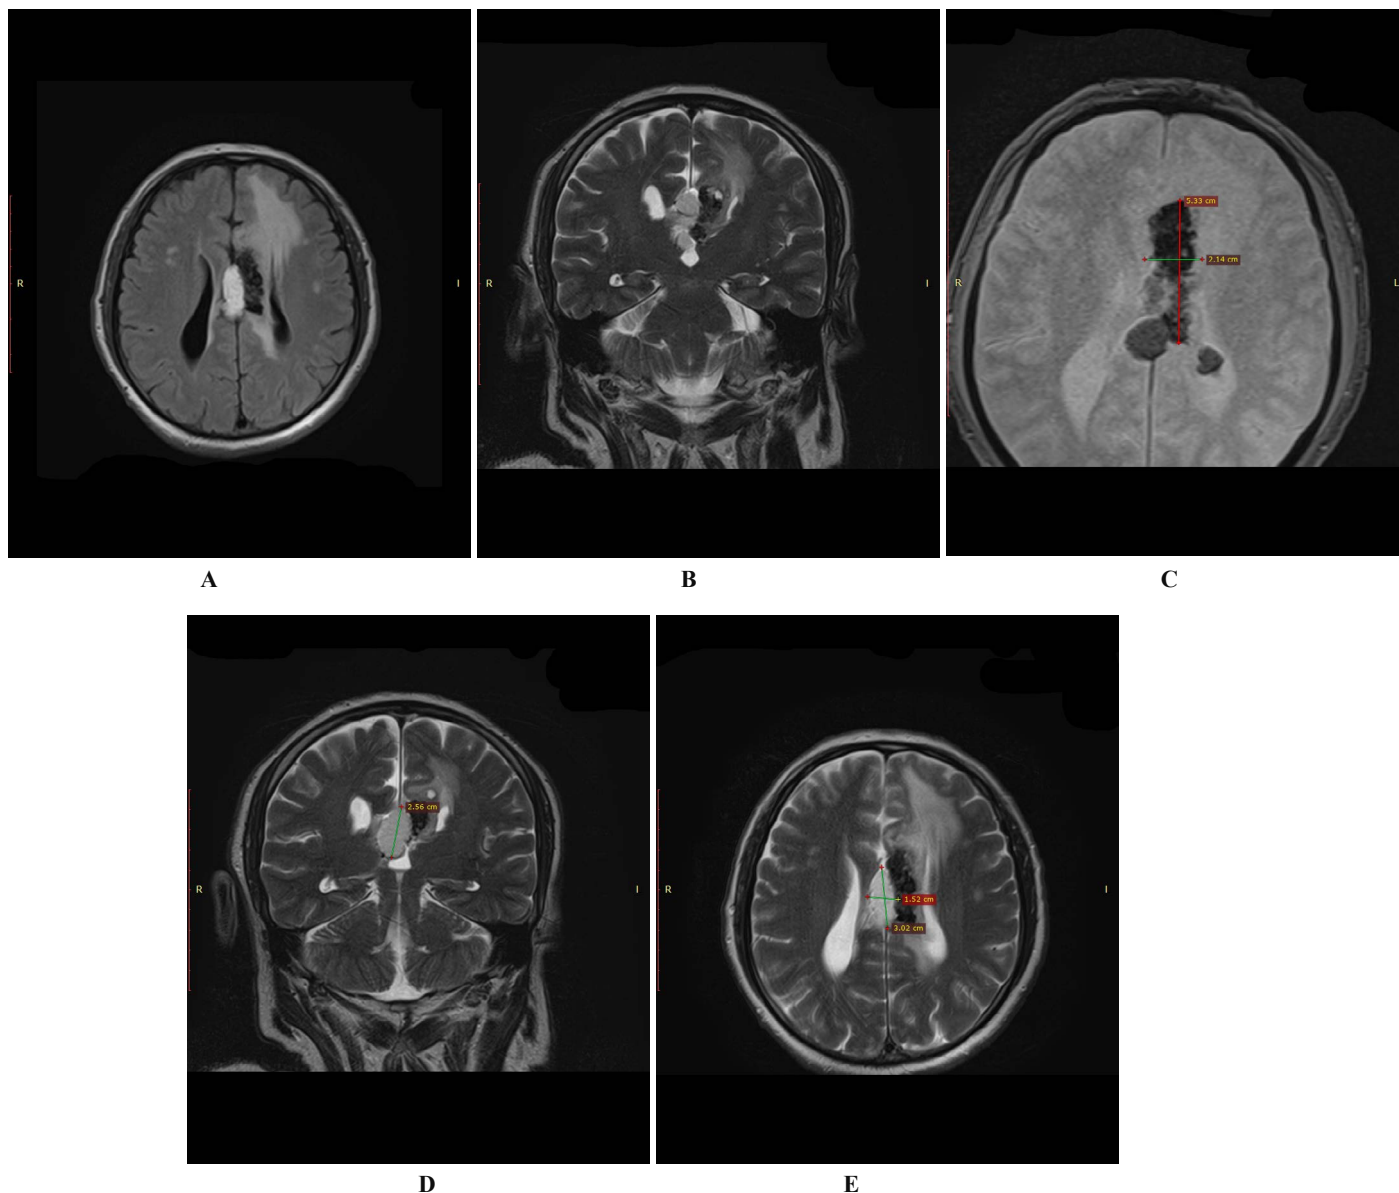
The MRI reveals a multilobulated, calcified mass in the left frontal lobe, encircled by edema. A) Axial Fluid Attenuated Inversion Recovery (FLAIR) sequence; B) Coronal T2-weighted Magnetic Resonance Imaging (MRI) sequence; C) Axial Gradient Echo sequence; D) Coronal T2-weighted sequence displaying an interhemispheric lipoma. E) Axial T2-weighted MRI demonstrating a multilobulated lesion in the left frontal lobe with central hypointense foci suggestive of calcification, measuring approximately 3.02×1.52 cm. The mass is associated with surrounding hyperintense signal indicating vasogenic edema and exerts mild mass effect on the adjacent frontal horn of the lateral ventricle.
